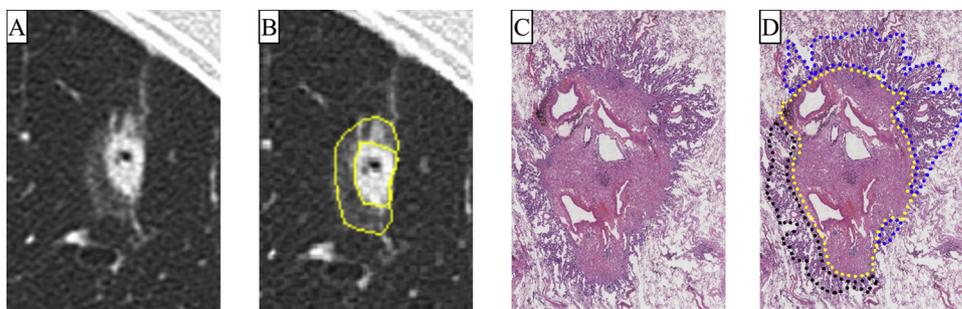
(A and B) Measurement of GGO proportion. Axial CT image showing a part solid lesion (A). The whole lesion and solid component were manually outlined and areas were measured using the texture analysis software ImageJ (B). Using these values, the proportion of GGO was calculated.
